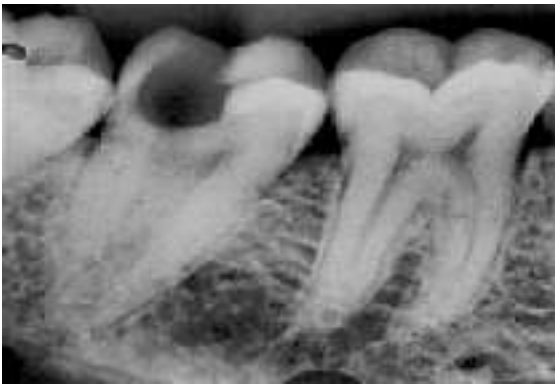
Pre-operative radiograph of tooth showing radiolucency involving enamel, dentin and pulp #47.
